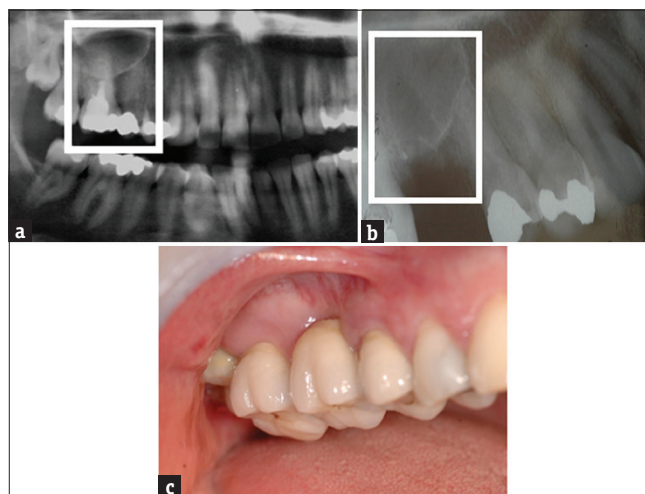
(a) Pre-operative orthopantomogram (OPG). The white rectangle limits the tooth to be extracted. The apical third of the roots seems to be in continuity with the sinus floor. (b) Endo-oral radiograph showing the site extracted. (c) The final prosthetic bridge
